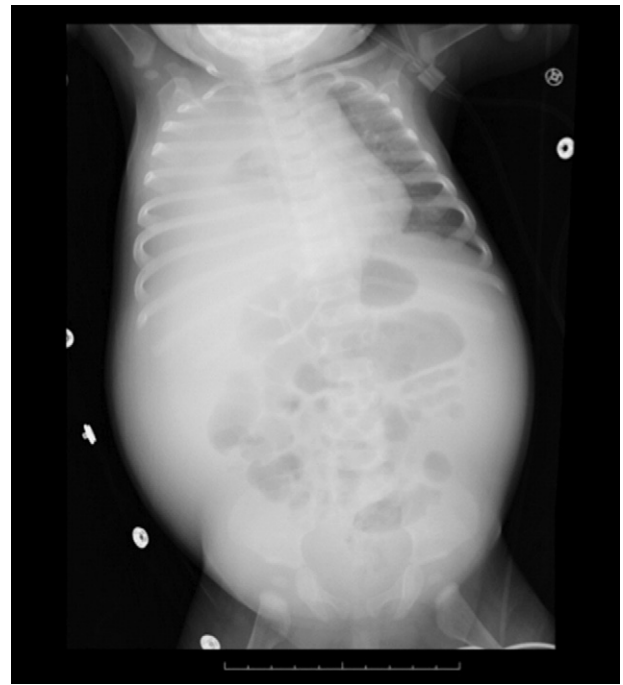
Thoracoabdominal X-ray showing right pleural effusion and ascites (case 1).
